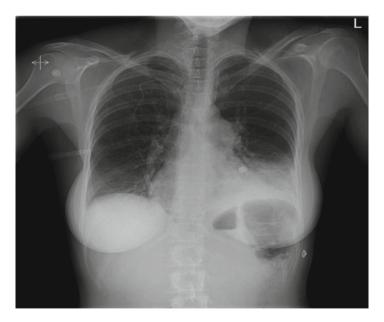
Chest X-ray of a 41-year-old woman with acute lymphoblastic leukemia receiving chemotherapy who presented to the EC with left-sided pleuritic chest pain and hypotension. She did not have fever, was neutropenic with a total white blood count of $400/\mu L$, and had a lactic acid level of 5.3 mmol/L. The X-ray demonstrates a left lower lobe infiltrate. This patient was septic and experienced rapid progression to septic shock with respiratory and multiple organ failure. Sputum and blood cultures were positive for *P. aeruginosa*
